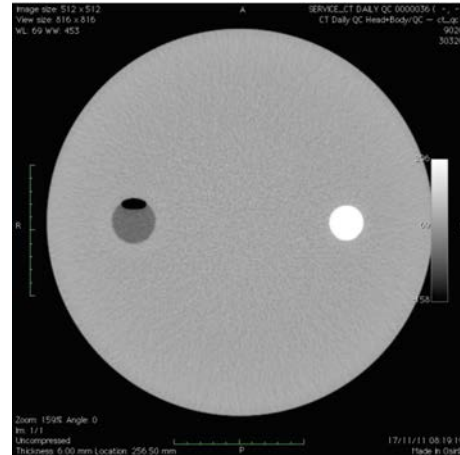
CT scan of the body layer.
